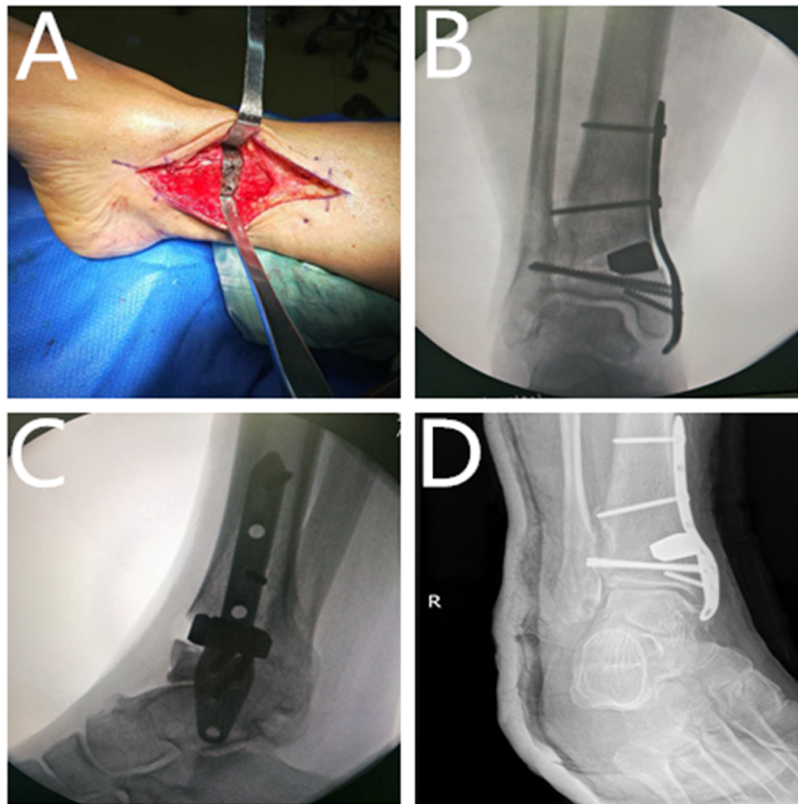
Typical case. (A) Implant the tantalum metal. (B) The intraoperative radiograph shows good correction position (anteroposterior view). (C) The intraoperative radiograph shows good correction position (lateral view). (D) The re-examined radiograph at 15 days postoperatively (anteroposterior view).
